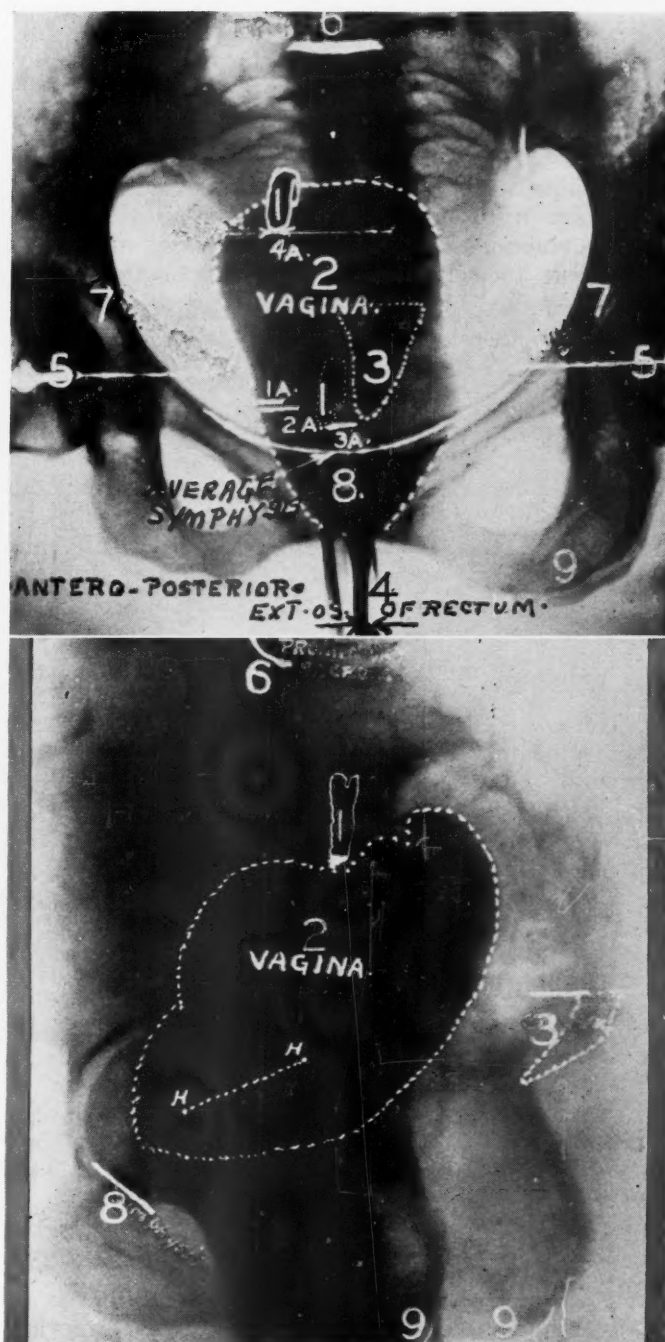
Shows the x-ray of a nulliparous vagina fully distended with 180 c.c. of a 3 per cent solution of sodium iodide. The anterior-posterior view appears above, the lateral view below.
